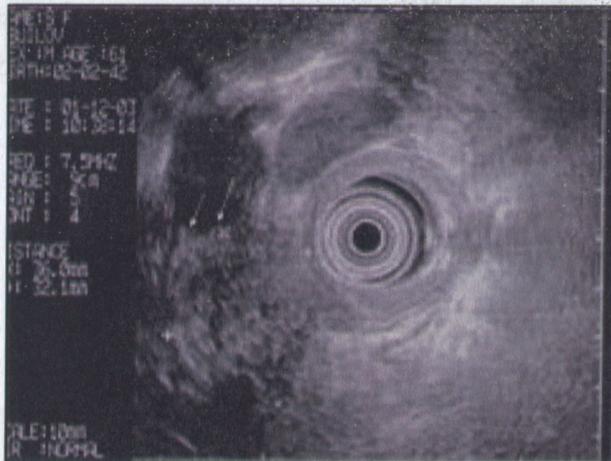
Endo-ultrasound. In the left upper quadrant mass lesion adjacent to the present-hooked appendage of pancreas
